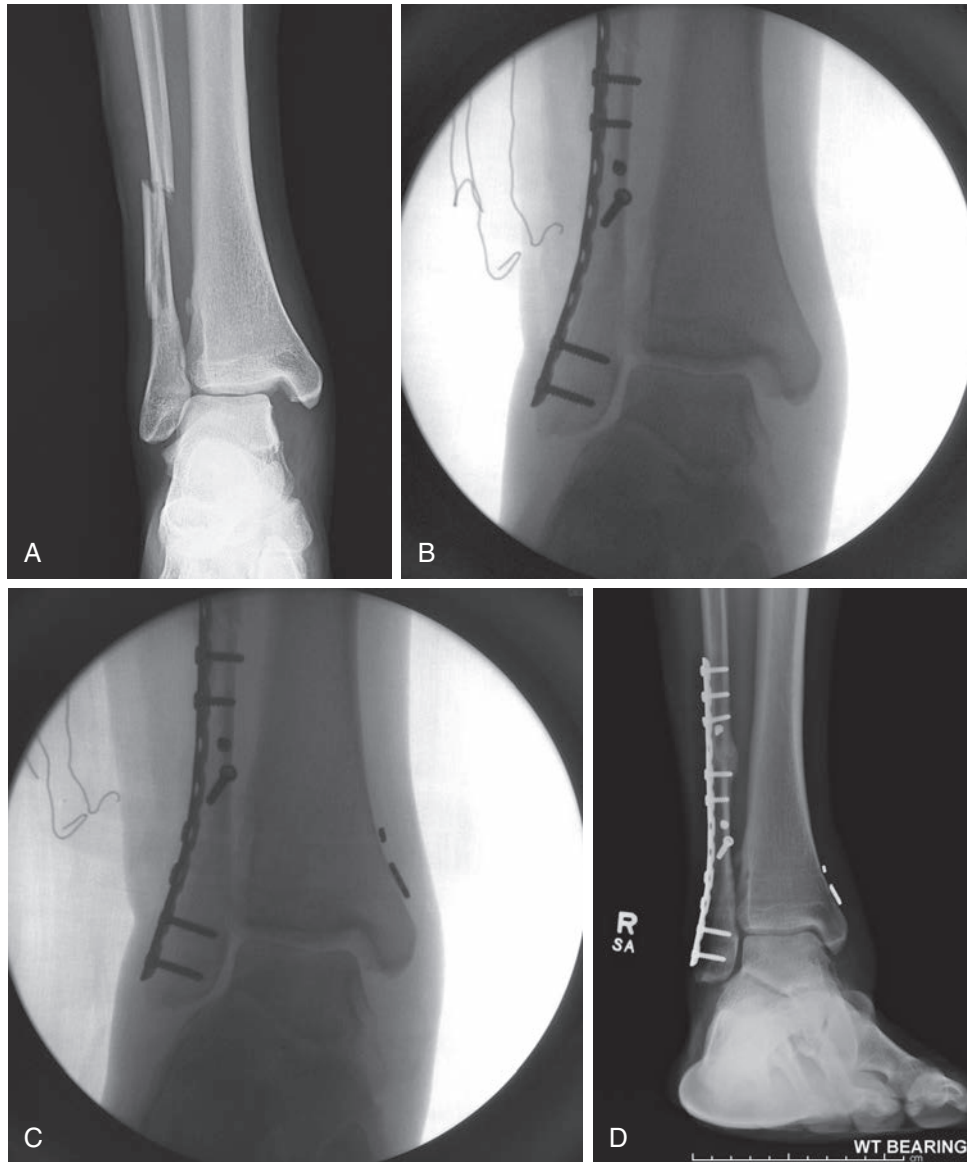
(A through D) (A) Preoperative radiograph of a trimalleolar equivalent ankle fracture in a collegiate football player. (B) External rotation stress after fibula fixation reveals medial clear space and syndesmosis widening. (C) Valgus stress after reduction and fixation of the syndesmosis reveals valgus tilt and medial clear space widening. Deltoid repair is performed to stabilize the medial ankle. (D) Final radiograph at 3 months postop reveals restoration of the ankle mortise and syndesmosis alignment.
